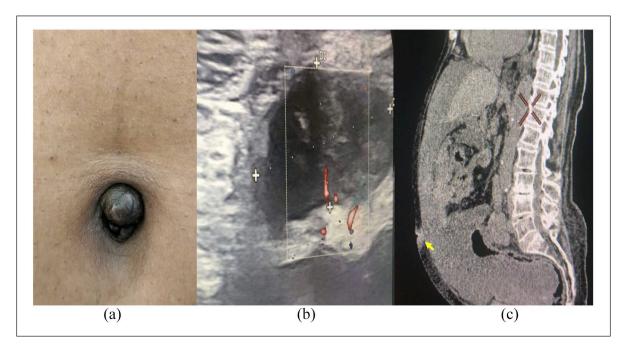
(a) Endometriosis presenting as an umbilical mass characterized by swelling and discoloration. (b) Abdominal ultrasound showing a non-vascularized subcutaneous mass with a tissue-like appearance at the umbilicus, measuring 24 mm × 19 mm. (c) The computed tomography examination reveals the presence of a tissue-based umbilical nodule that does not extend beyond the muscle layer.
